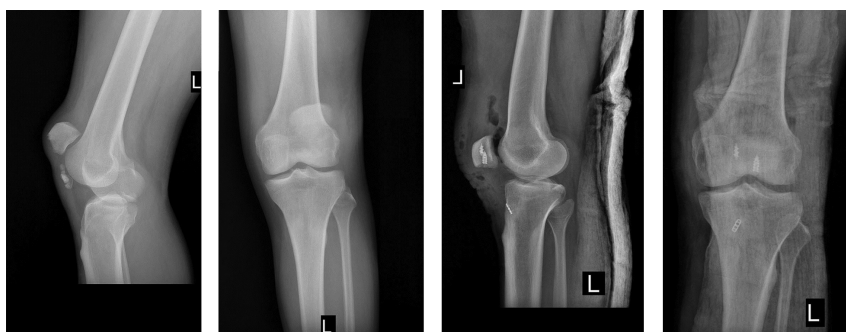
Anteroposterior and Lateral Pre and Postoperative Radiographs of a Patient with Partial Patellectomy.
